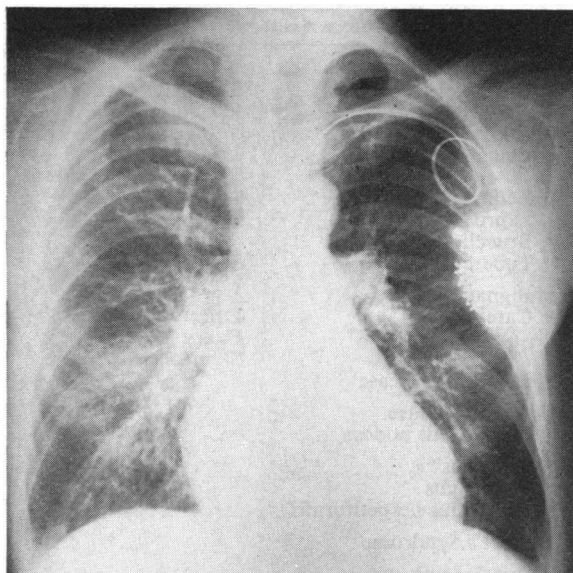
Radiographic film taken in April 1969, showing increased heart size.
